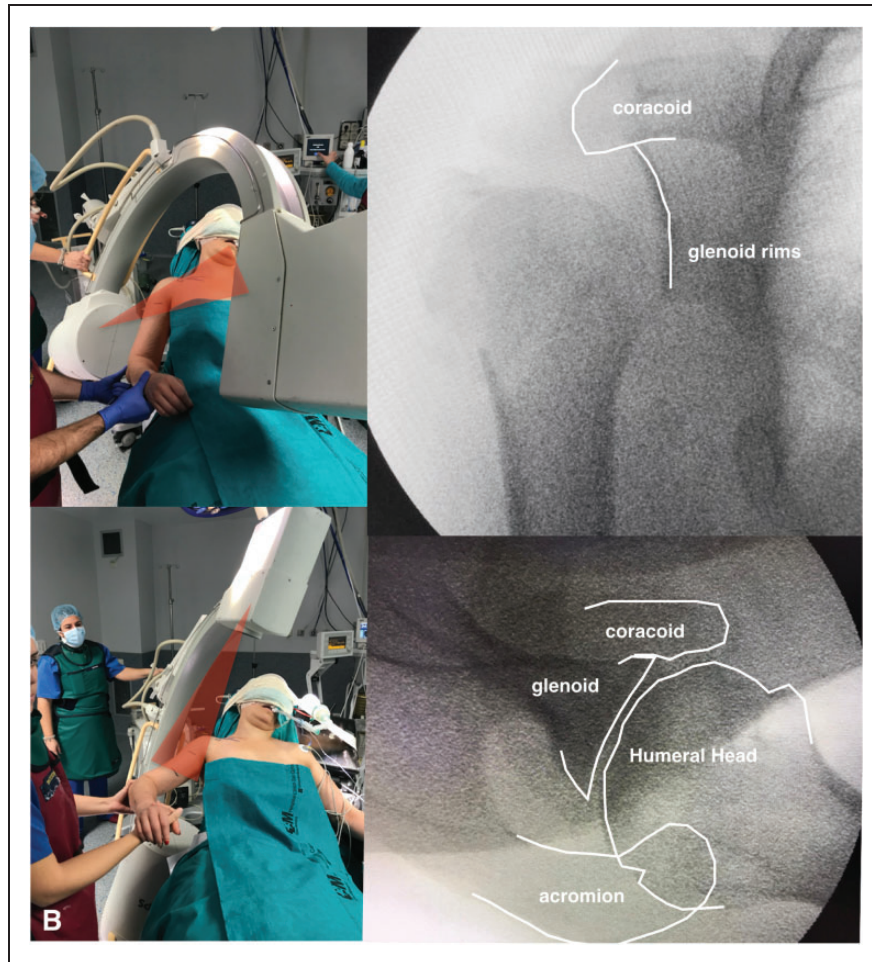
Fluoroscopy positioning. The device is brought into the surgical field from posterolateral to anteromedial and the C-arm is inverted so that the X-ray tube is placed at the top and the image intensifier at the bottom. (a) True anteroposterior scapular view: there should be no overlap between the glenoid fossa and the humeral head, the anterior and posterior glenoid rims are superimposed, and the coracoid process overlaps the glenohumeral joint. (b) Axial view: the joint space between the glenoid fossa and the humeral head must be clearly visualized, with the superior and inferior edges of the glenoid fossa superimposed and the lateral margin of the coracoid base aligned with the glenoid fossa.
